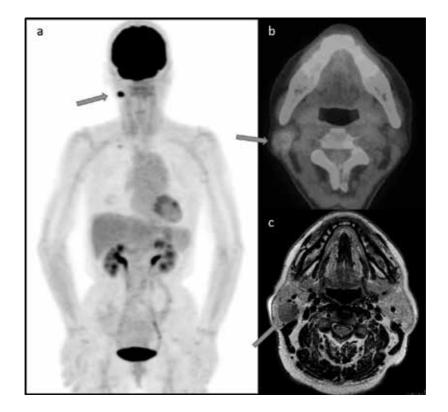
Warthin's tumor. (a). PET MIP image. (b). PET/CT fusion image. (c). T1-weighted MRI image. FDG is strongly taken up by the tumor (SUVmax: 9.4) in the right parotid gland. MRI also provides many findings consistent with malignancy. Salivary gland scintigraphy is useful for differentiation.
